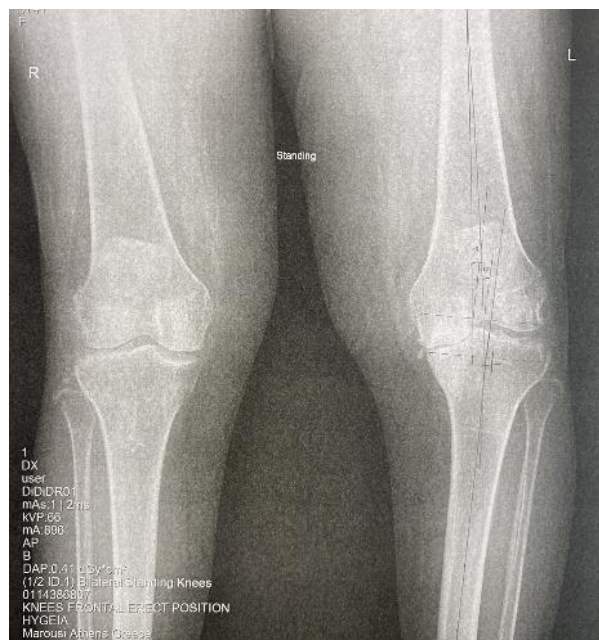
Pre-operative x-ray showing the severe left knee arthritis and varus deformity
